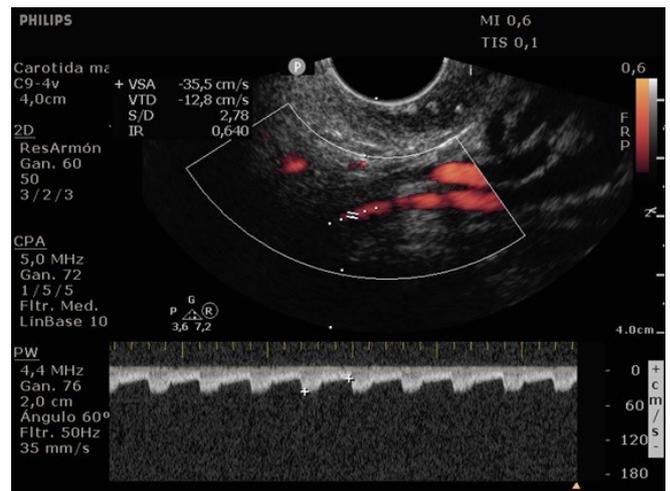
Transoral ultrasonography using pulsed wave Doppler.
